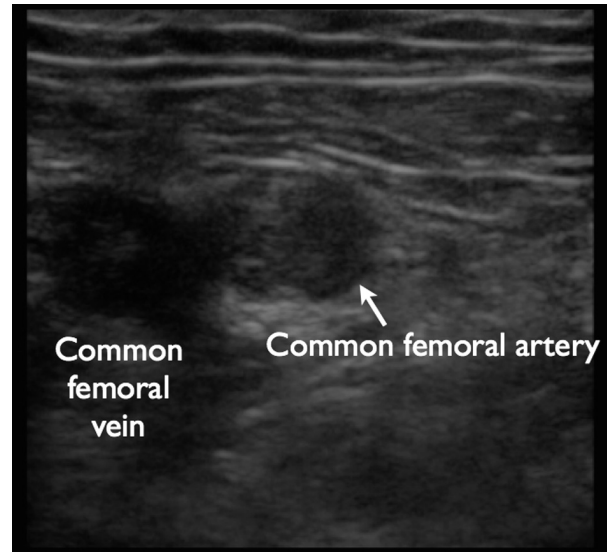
Transverse B-mode ultrasound image of the left common femoral artery and vein. Echogenic material can be seen in the left common femoral artery.
